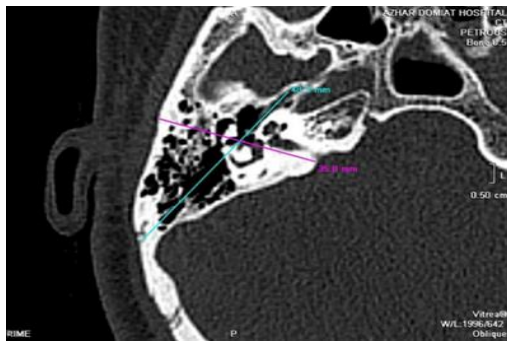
CT Temporal Bone Axial view
